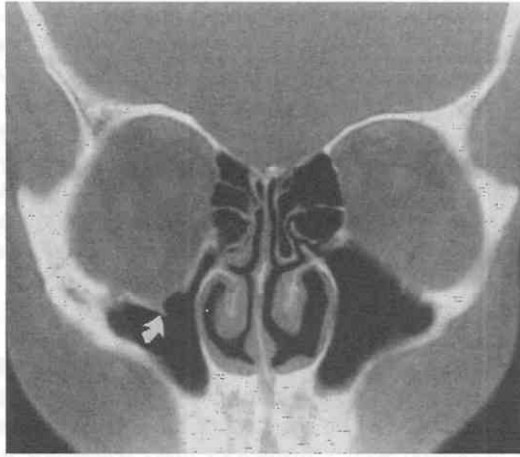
Inferior orbital wall fracture. Coronal CT scan reveals a fracture in the inferior wall of the right orbit with downward displacement of the fragment (*curved arrow*) but without herniation of the orbital contents.
